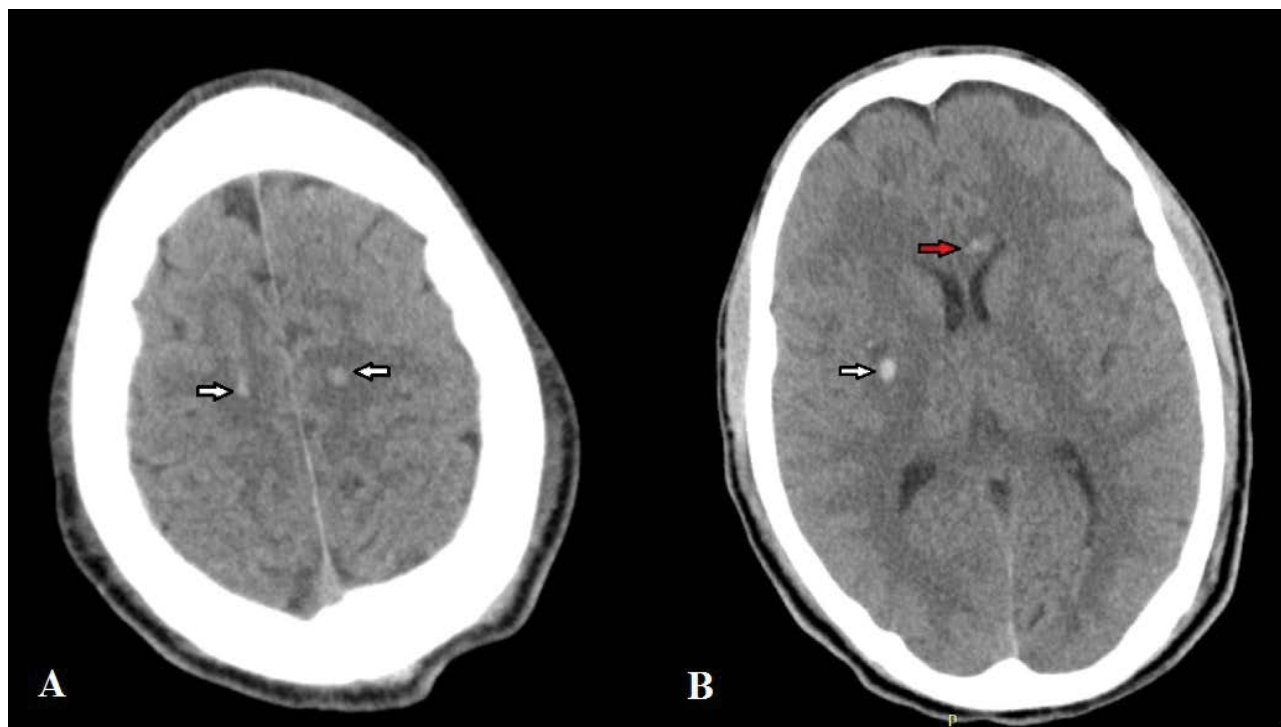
CT of a 22-year-old patient with severe TBI and clinical manifestation of DAI after a road traffic accident: A): DAI Grade I with bilateral hemispheric hemorrhagic lesions (white arrows); B): DAI Grade II with basal ganglia (white arrow) and corpus callosum hemorrhagic lesions (red arrow).
